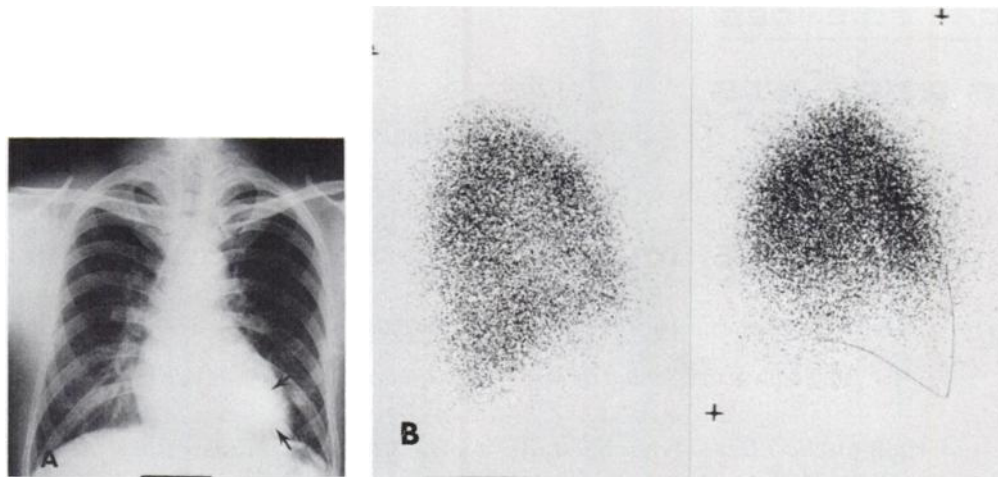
(A) Chest roentgenogram reveals a well-defined circular shadow, about 5 cm in diameter, behind the heart (arrows). (B) Lung scintigraphy shows perfusion defect to posterior basal region of left lung. Right lateral view is to viewer's left; left lateral view to viewer's right.
